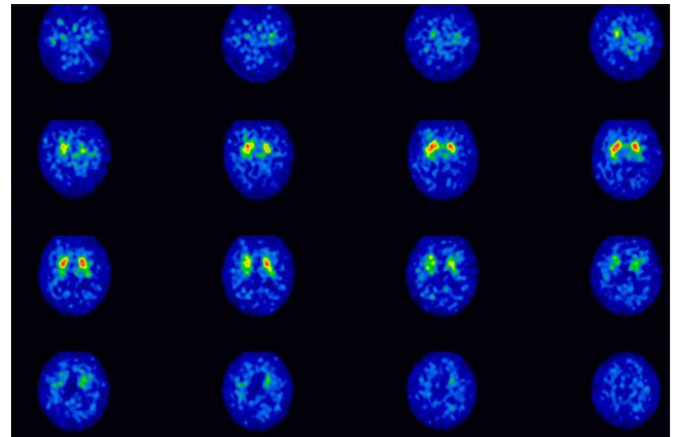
I-ioflupane Brain SPECT Study (Datscan) (1,2,3). There is reduced uptake in the striatum supporting the clinical impression of dementia with Lewy bodies.
